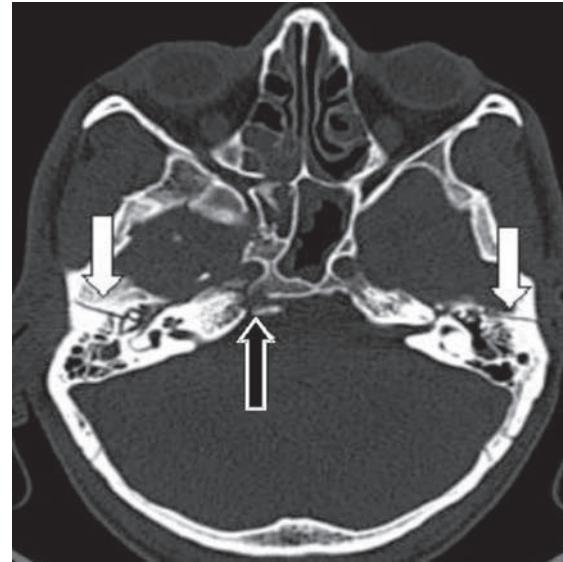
CT scan showing fractures at the right petrous apex (empty arrow) and of both petrous bones (block arrows)
